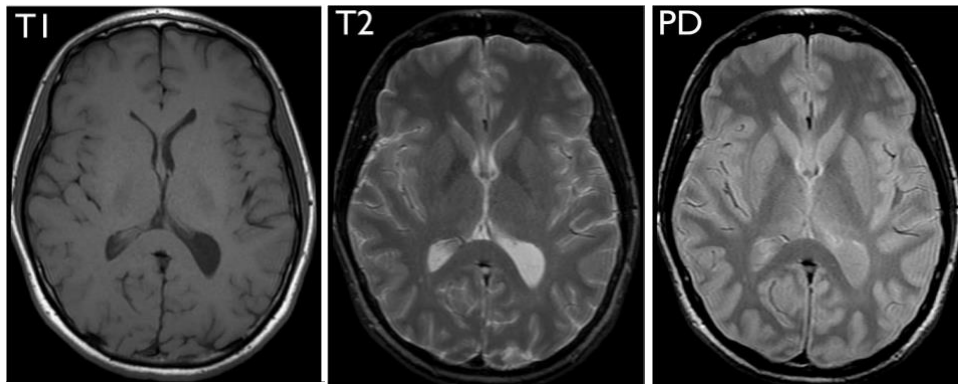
MRI images with different weighted contrast, T1-W, T2-W and PD. Reprinted from <https://radiology.ucsf.edu/blog/neuroradiology/exploring-the-brain-how-are-brain-images-made-with-mri>
